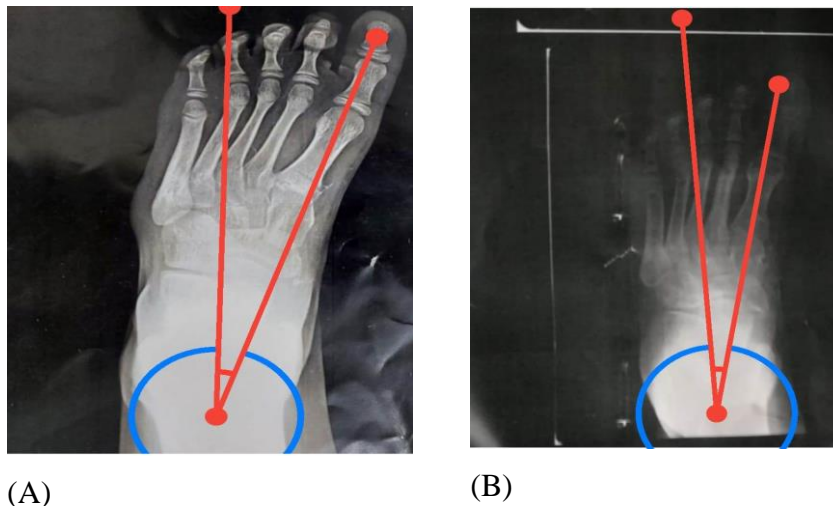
A) pre-operative x-rays AP view of Lt foot shows talo first metatarsal angle = 17°, B) Post-operative x-rays AP view of LT foot shows talo first metatarsal angle = 15°
